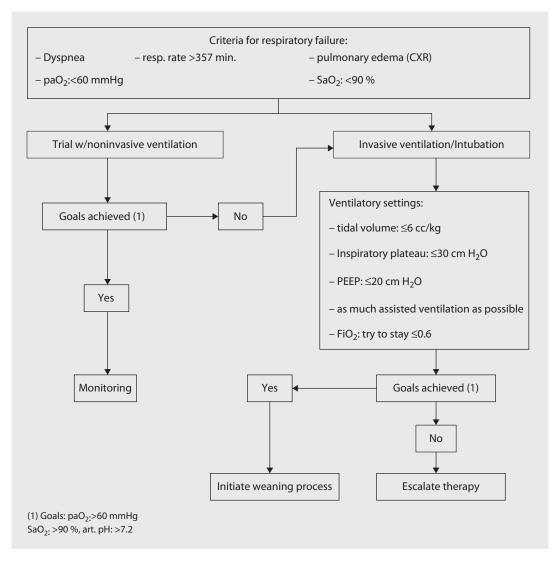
Our initial therapeutic approach in acute respiratory failure/acute pulmonary failure. *FiO*₂ inspired oxygen fraction, *paO*₂ arterial oxygen partial pressure, *PEEP* positive end-expiratory pressure, *CXR* chest X-ray, *SaO*₂ arterial oxygen saturation
